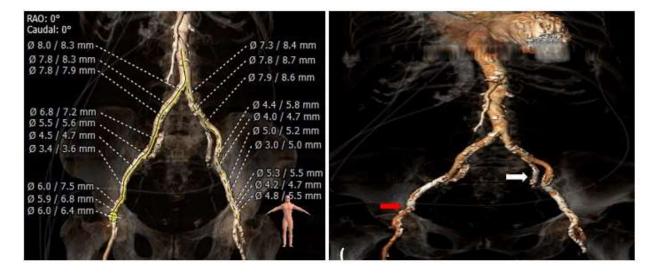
a,b: CT images; showing arterial tree with various dimensions (a). Narrowest calcified portion in the right external iliac (red arrow), and tortuous, heavily calcified left iliac artery (white arrow) (b).
